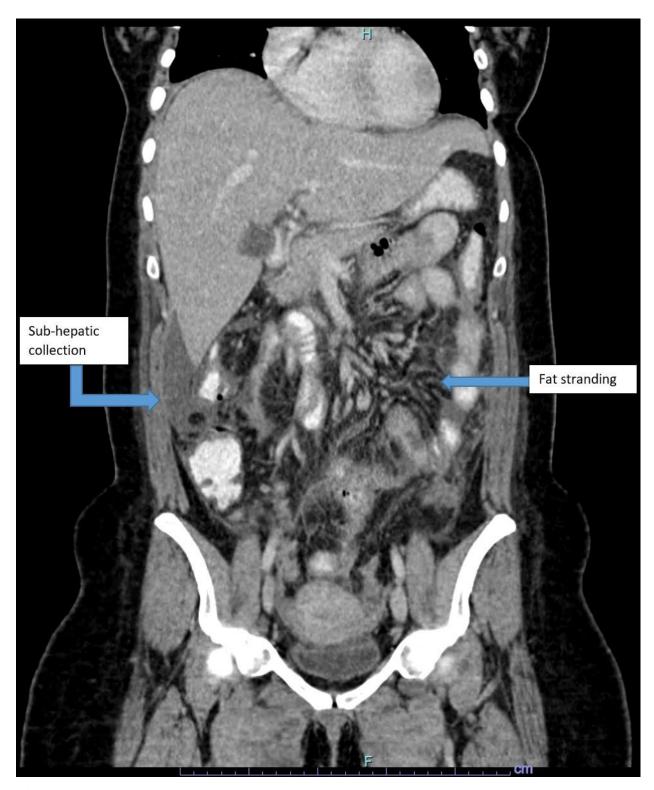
Postoperative CT –abdomen with signs of acute inflammation
